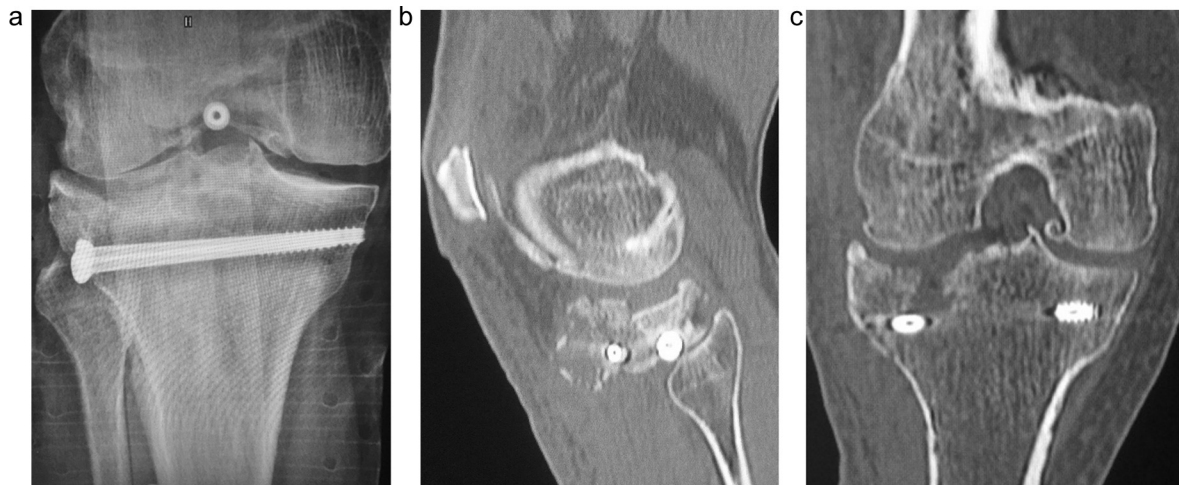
Anteroposterior postoperative radiograph showing depressed external tibial plateau fixed by two cannulated screws (a). Postoperative CT scans on sagittal (b) and coronal (c) views showing lateral split with important articular defect.
